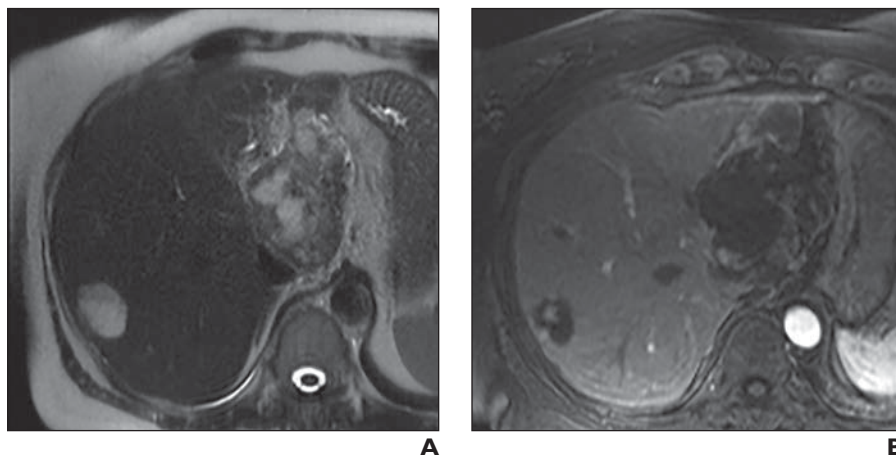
57-year-old woman with nonalcoholic fatty liver disease. Example of hyalinized hemangioma. Initial images (A–D) show one lesion present in segment VI and one exophytic lesion arising from segment IVB in porta hepatis. Segment VI lesion has high signal intensity on T2-weighted image (A), whereas exophytic lesion is more complex, with areas of lower signal intensity in its periphery and interspersed in its center. Both lesions had diminished signal intensity on T1-weighted images (not shown) and nodular interrupted peripheral enhancement with centripetal filling on later phase contrast-enhanced images (B–D). Four years later (E–H), changes likely related to hyalinization of hemangiomas are present. Both lesions (*arrows*, E–H) are smaller than earlier examination (A–D), less well defined, have lower signal intensity on T2-weighted images, and have less classic enhancement pattern on early phases after contrast material administration (F and G) with filling in on 5-minute delayed phase image (H).
